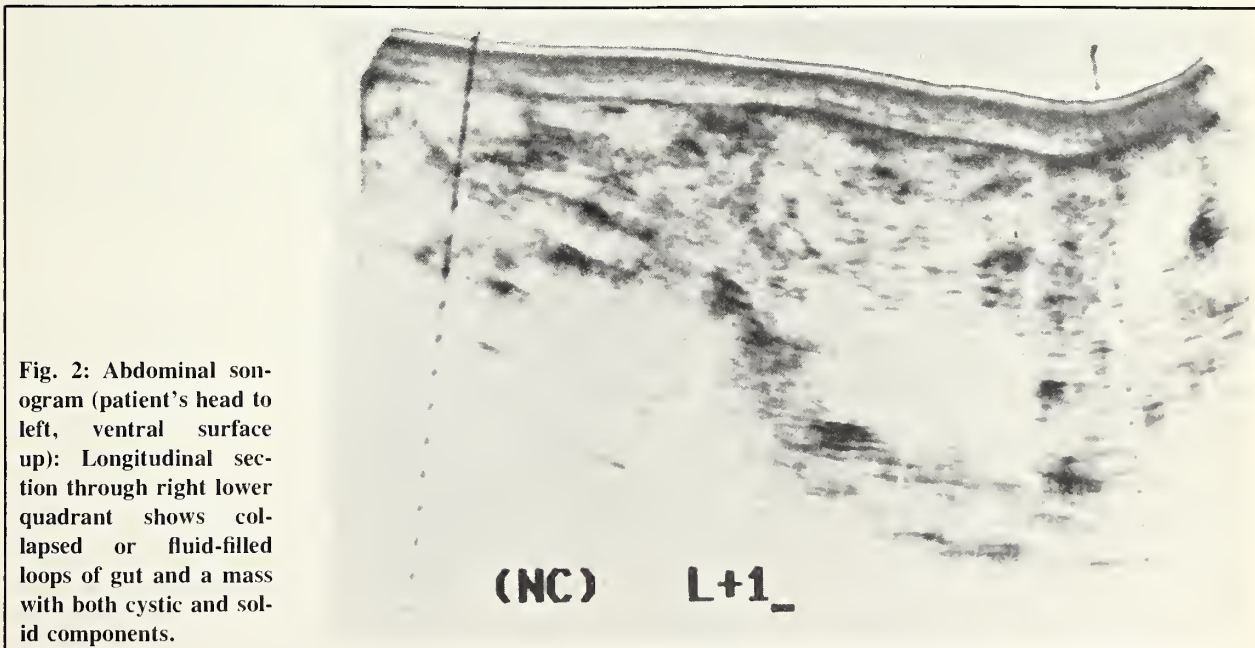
Abdominal sonogram (patient's head to left, ventral surface up): Longitudinal section through right lower quadrant shows collapsed or fluid-filled loops of gut and a mass with both cystic and solid components.
